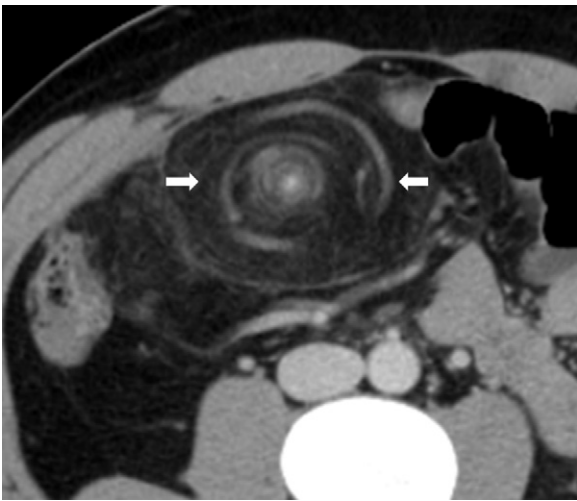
CT shows linear strands in a concentric pattern (arrows).
